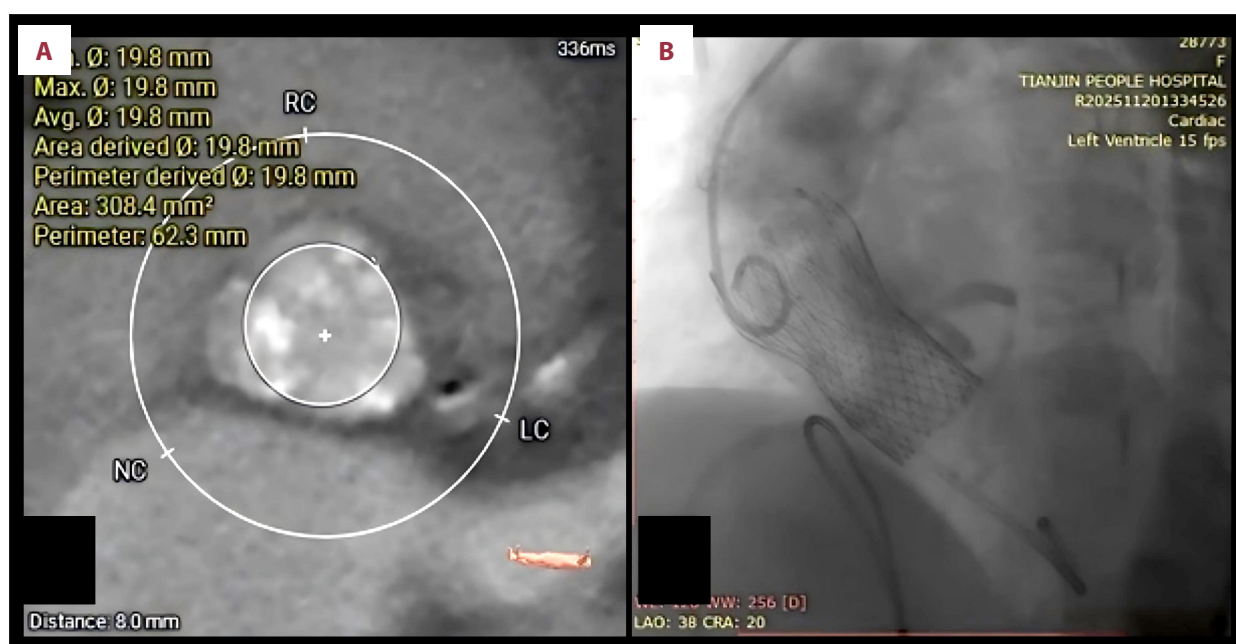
Preoperative transcatheter aortic valve replacement evaluation and postoperative imaging. (A) Preoperative CTA assessment showing a tri-leaflet valve with leaflet calcification, thickening, and partial adhesion. (B) Postoperative imaging showing the implanted valve.
